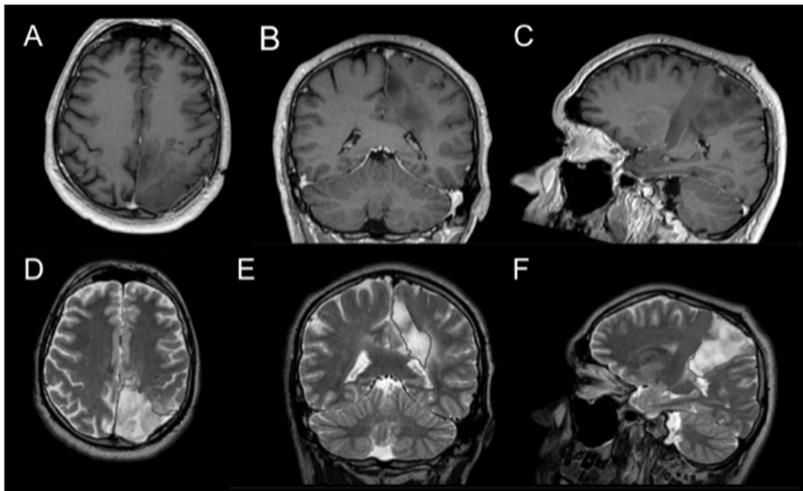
Intraoperative use of navigation with fiber tracking data to increase the safety of brain tumor surgery. Navigation with fiber tracking data using (A, D) axial, (B, E) coronal and (C, F) sagittal contrast-enhanced T1-weighted images (*above*) and T2-weighted images (*below*) to limit resection of brain tumors in and near the central motor region and minimize the risk of postoperative neurological deficits.
